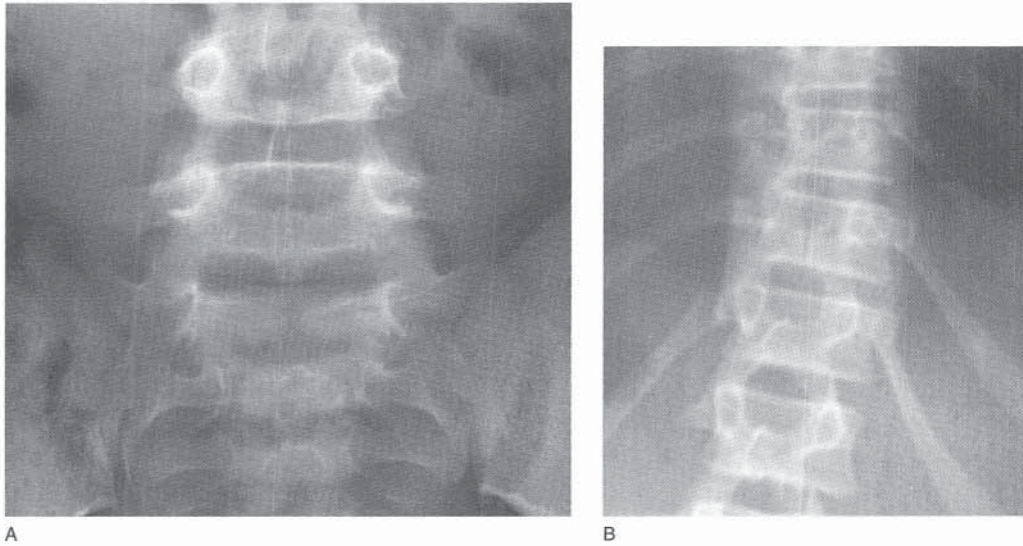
Appearance of spina bifida occulta noted incidentally on spinal radiographs. If there are no complaints or physical abnormalities, further investigation is unnecessary. A, The most common level of spina bifida occulta is at L5 or S1. B, Spina bifida occulta of T11 noted incidentally on spinal radiographs taken to evaluate scoliosis. Spina bifida occulta may also be seen in the lower cervical spine.
